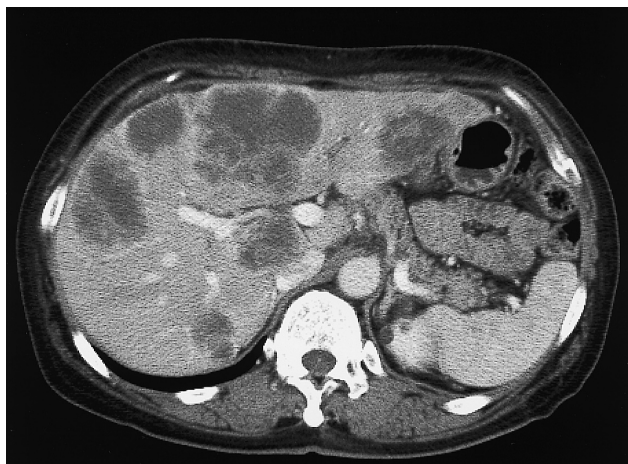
A 58-year-old woman with multiple liver metastases from cancer of the descending colon. Contrast-enhanced CT image obtained before the initiation of HAIC showing multiple unresectable liver metastases in both the right and left lobes of the liver.
